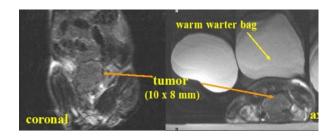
MR images showing the prostate tumor in the coronal view and axial view.
